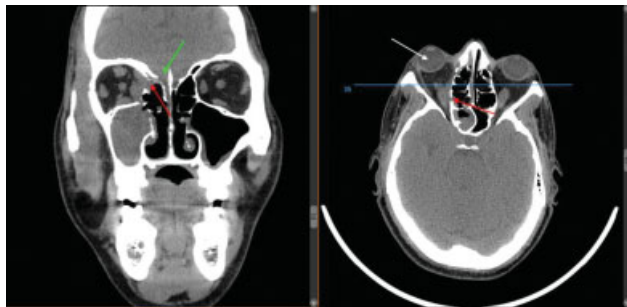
Computed tomography showing right lamina papyracea multifocal dehiscence (red arrow) with intraorbital extension of disease, resulting in proptosis (white arrow). There is right anterior skull base dehiscence (green arrow), which raises suspicion for intracranial extension of disease.
